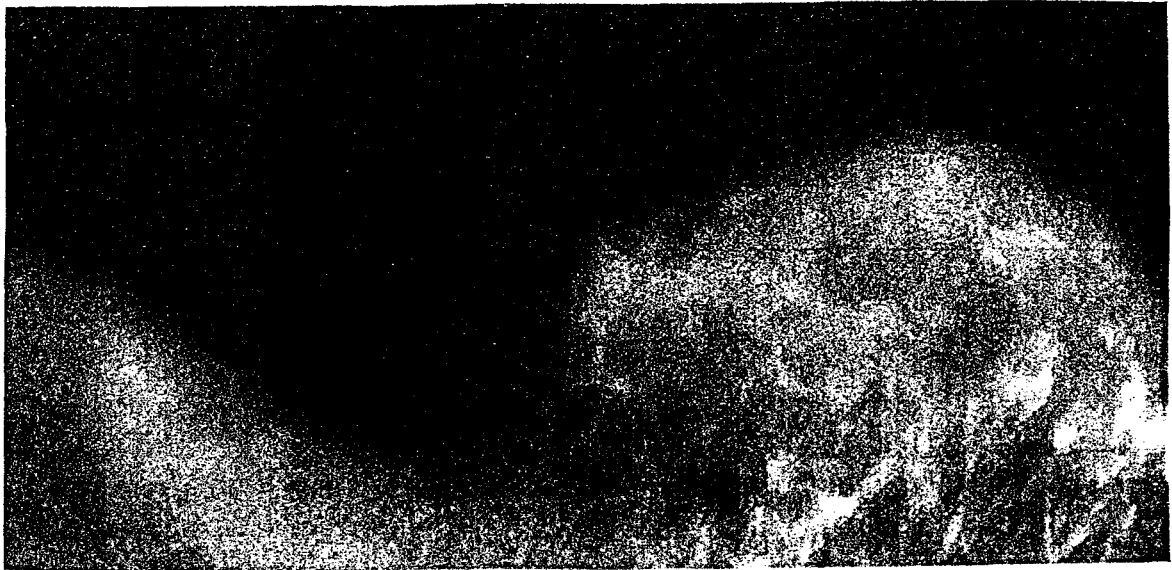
(a) Left side breast, x-ray image.
